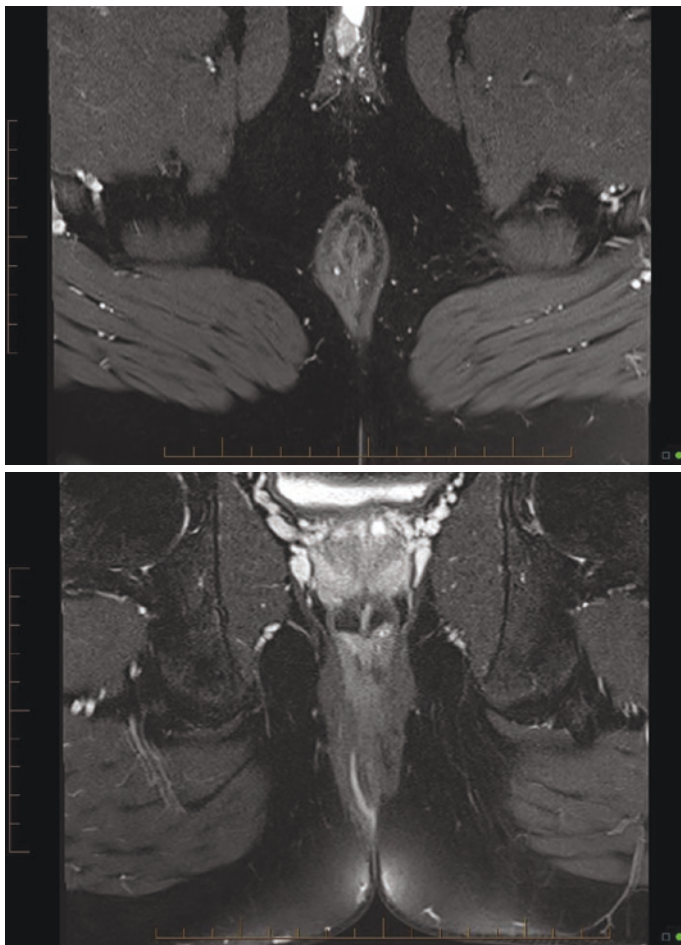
Axial and coronal MR imaging of linear intersphincteric perianal fistula. Note the fistula track lies deep to the external anal sphincter muscle in both planes
